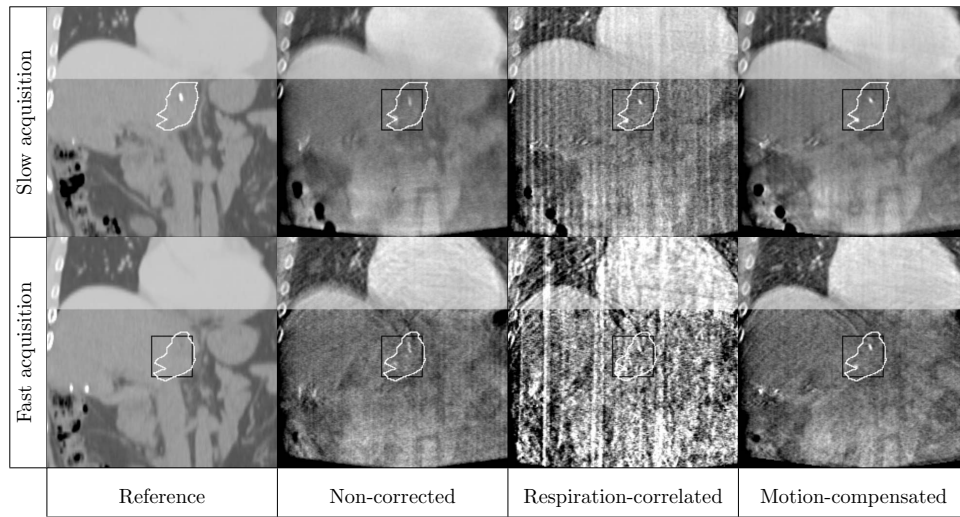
Coronal slices of the reference CT image and CBCT images reconstructed from the two data sets acquired on the liver patient. The white lines delimit the GTV and the black lines the plot of Fig. 12. Gray level windows: $[-500;1500]$ for the thorax and $[600;1300]$ for the abdomen.
